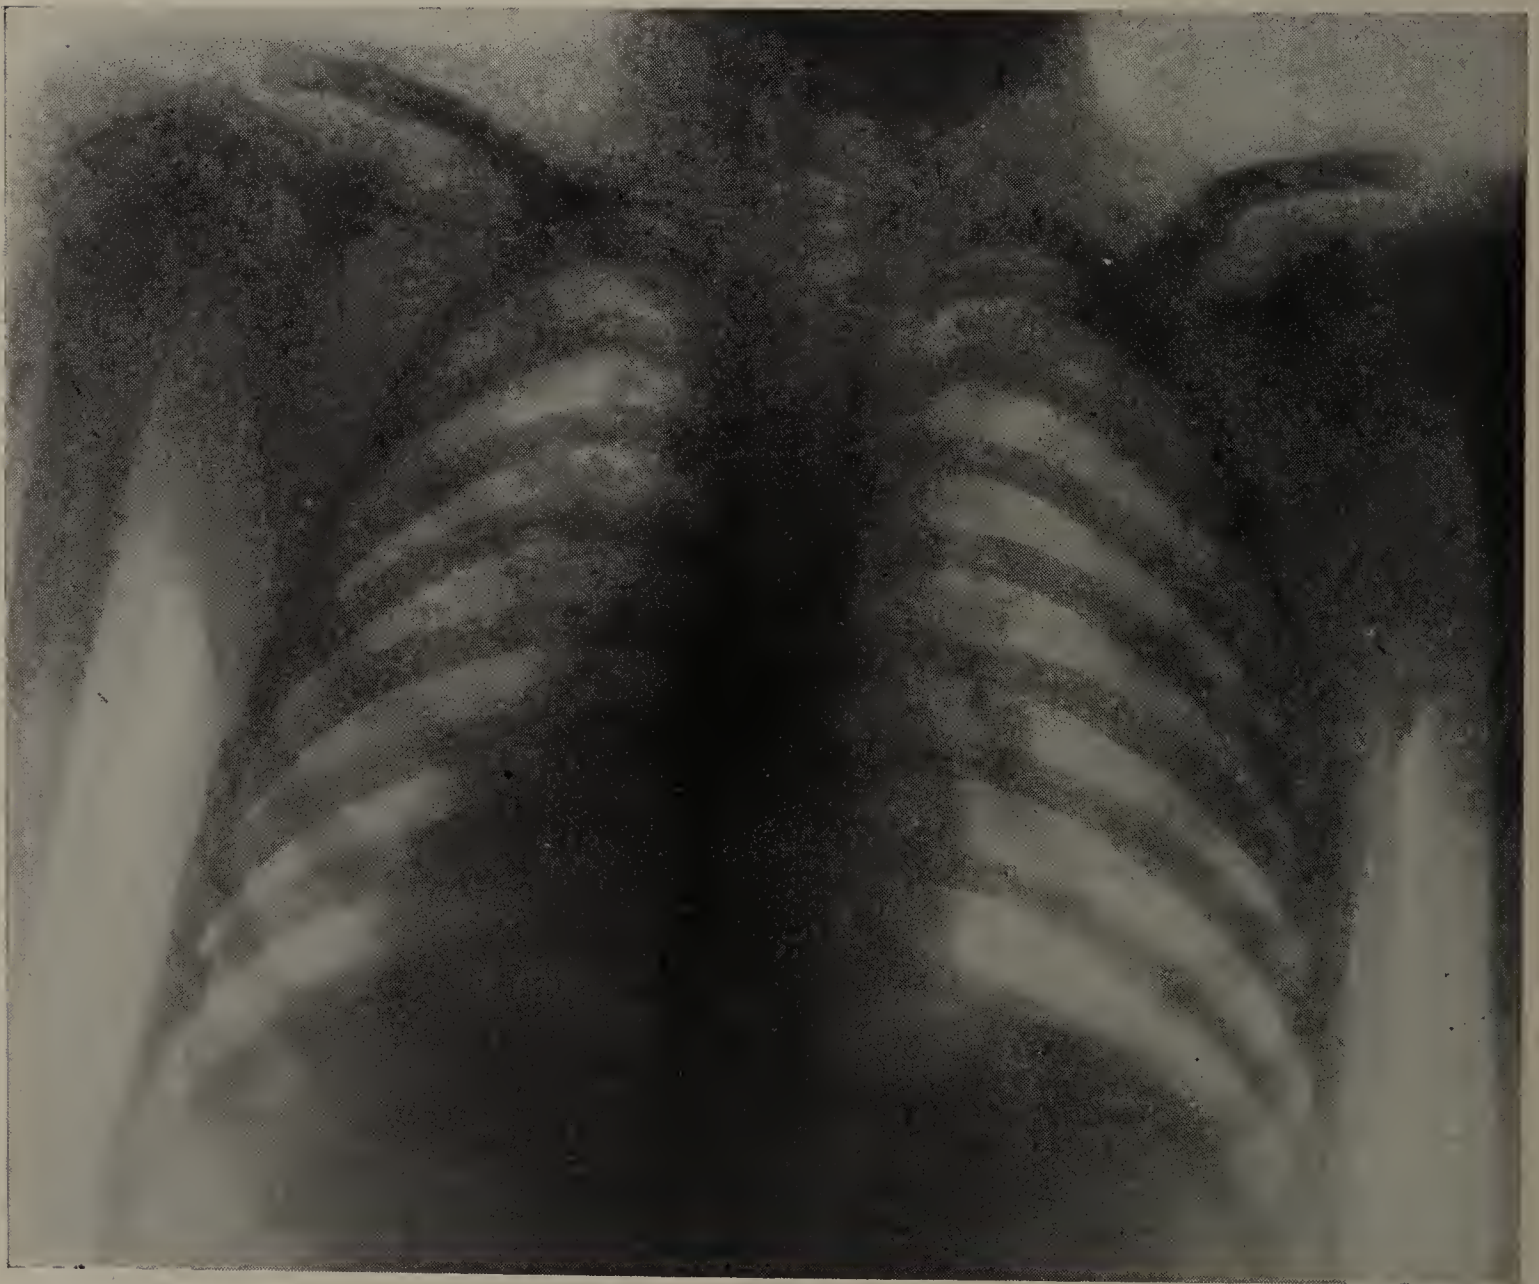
Christine P. Cut from radiograph which was made on the same day that the radioscopy tracing was drawn. X-ray tracing (see Fig. 102) shows well-marked signs.
